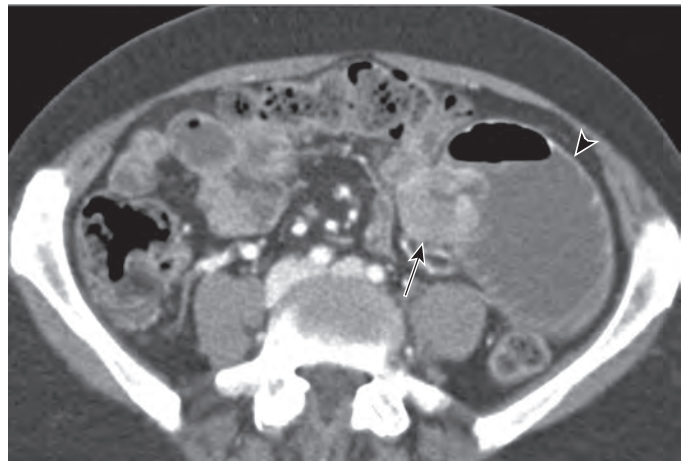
Typical findings of small bowel adenocarcinoma. Axial CT on a 67-year-old presenting with small bowel obstruction. There is an annular, constricting mass (arrow) in the proximal jejunum, with upstream bowel dilation (arrowhead). The location of this tumor and its imaging findings are characteristic of adenocarcinoma.
